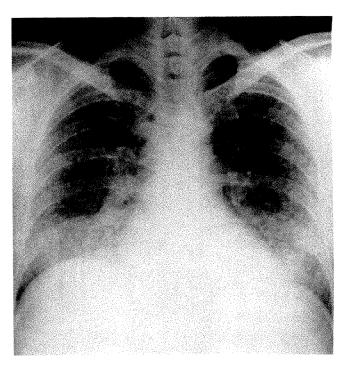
Chest radiograph 2 days after onset of symptoms shows well-circumscribed, small nodular densities in both lungs, predominantly at periphery.
